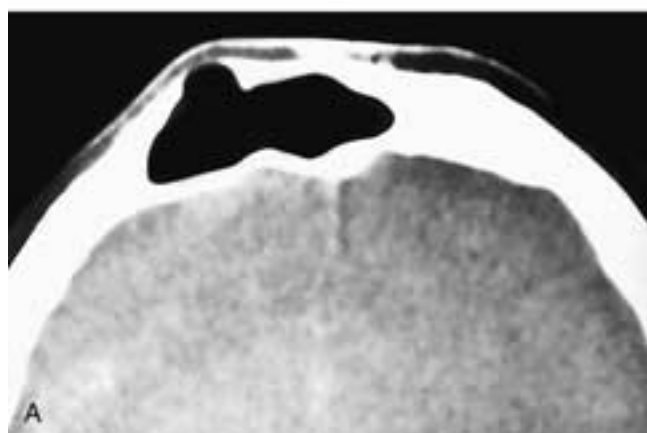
A, Axial CT scan shows a normal-sized right frontal sinus that has focally thinned the anterior sinus wall, causing a bulge in the forehead. This patient had a pneumocele. B, Axial CT scan on another patient shows a minimally expanded right frontal sinus with thinning of the anterior table. This patient also had a pneumocele.
